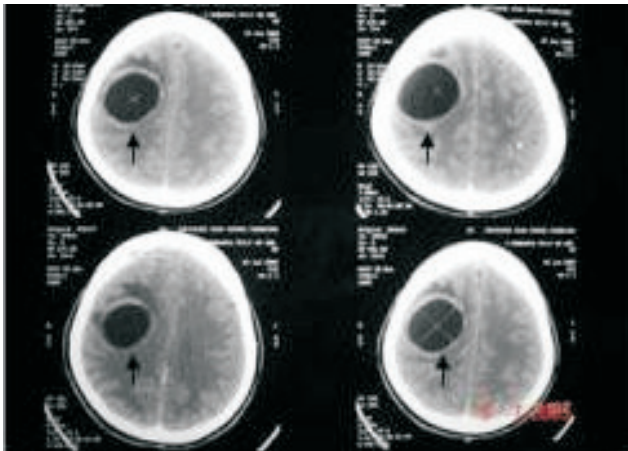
CT scan brain showing a hypochoic lesion in left frontoparietal region
